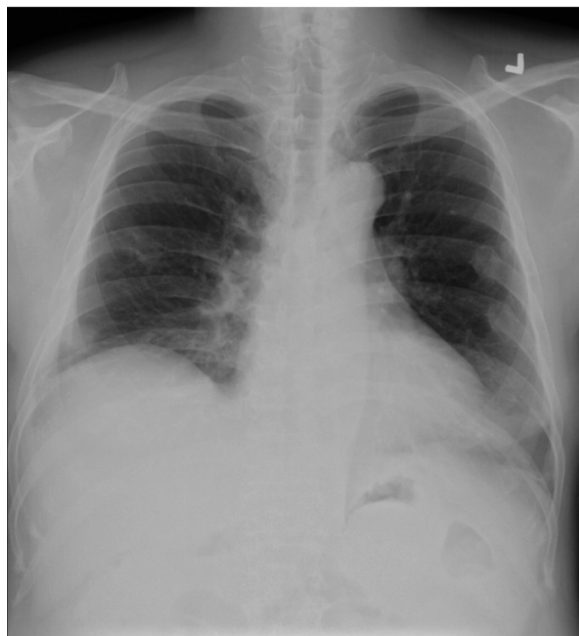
Chest X-ray posterior-anterior (PA) upright view performed 1 month after treatment onset showing significant improvement in the abscesses.
